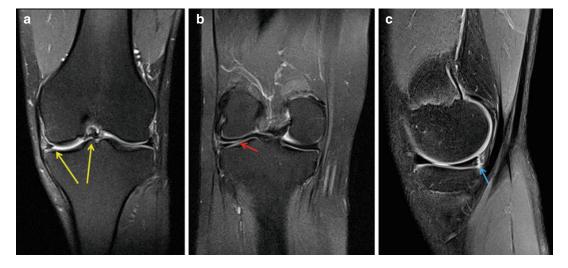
MRI T2 images of: medial meniscus bucket-handle tear (*yellow arrows*) (a), lateral meniscus horizontal cleavage tear (*red arrow*) (b), and medial meniscus complete longitudinal peripheral tear (*blue arrow*) (c)
